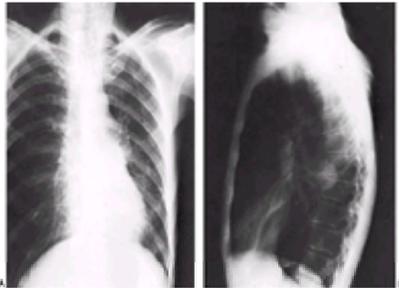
A: Carcinoma of the lung hidden behind the cardiac silhouette on posteroanterior roentgenogram. B: Lateral view of the chest reveals the carcinoma. (Reprinted with permission from Morgan WKC, Hales MR. Bronchogenic carcinoma. In: Baum GL, Wolinsky E, eds. *Textbook of Pulmonary Diseases*. 3rd ed. Boston: Little, Brown; 1983.)
